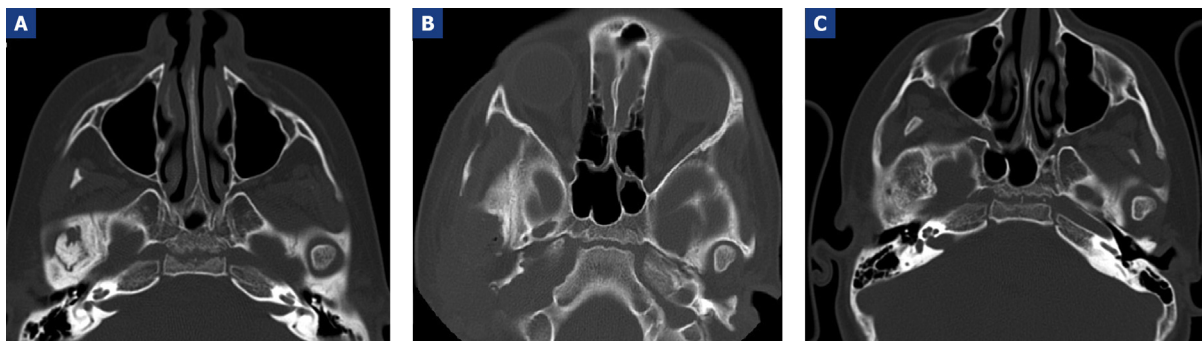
CT scan, axial view; A: before surgery scan showing the radiolucent peripheral area between the condyle and surrounding bone structures; B: after surgery scan where showing the absence of the right condyle in the glenoid fossa; C: one year after surgery scan, showing completely remodeled floor of the middle cranial fossa.
